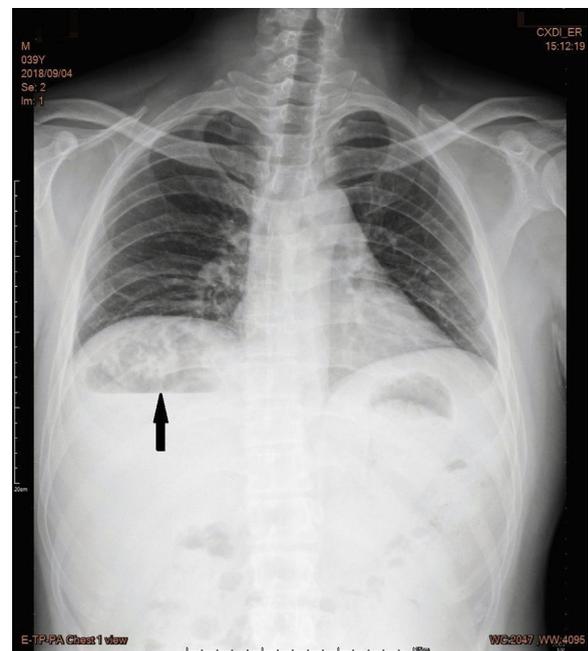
Chest x-ray study showing a heterogeneous radiodensity with air-fluid level lesion over the right upper abdomen.
